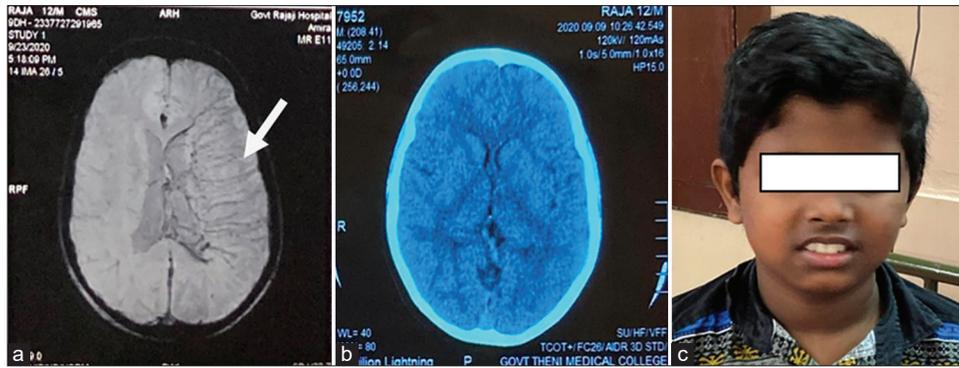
(a) Magnetic resonance imaging brain SWI film showing trans parenchymal medullary veins connecting subependymal vein with cortical veins. (b) Computed tomography brain plain axial cut shows normal study. (c) patient picture without skin manifestation
